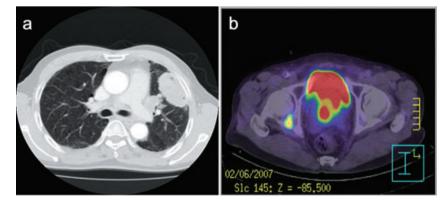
(a) Chest CT shows a tumour mass in the left lingular segment. (b) PET shows strong focal uptake in the prostate.
